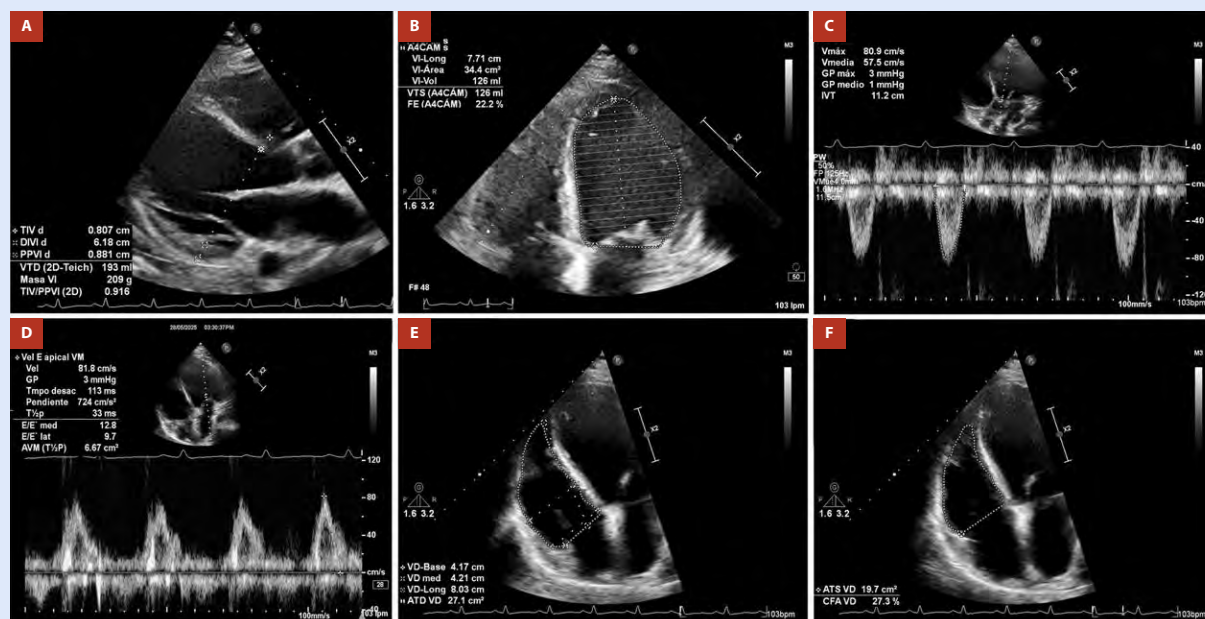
Transthoracic echocardiography demonstrates severe biventricular systolic dysfunction. A. Parasternal long-axis view showing a markedly dilated LV (end-diastolic diameter 61 mm). B, C. Apical four-chamber view demonstrating severe global LV systolic dysfunction; biplane Simpson LVEF was 22%. D. Pulsed-wave Doppler showing a reduced LVOT VTI: 11 cm, consistent with low forward stroke volume in the context of advanced HF. E. RV-focused apical four-chamber view showing RV dilatation. F. RV FAC reduced to 27%, confirming significant RV systolic dysfunction.
